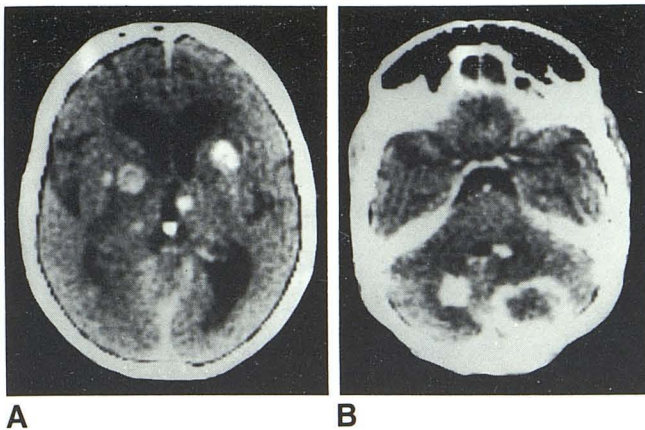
Contrast-enhanced CT scans. A, Lesions in head of left caudate nucleus, both thalami, and right internal capsule and putamen. Mild hydrocephalus. B, Large, ring-enhancing lesion in left cerebellar hemisphere, displacing fourth ventricle anteriorly and dextrad; smaller, homogeneously enhancing lesion in right cerebellar hemisphere; third lesion adjacent to left side of fourth ventricle.
